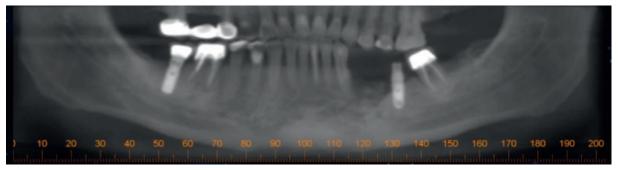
Panoramic radiograph after the piece of bone come out and root canal therapy was performed on the mandibular lateral incisor.
